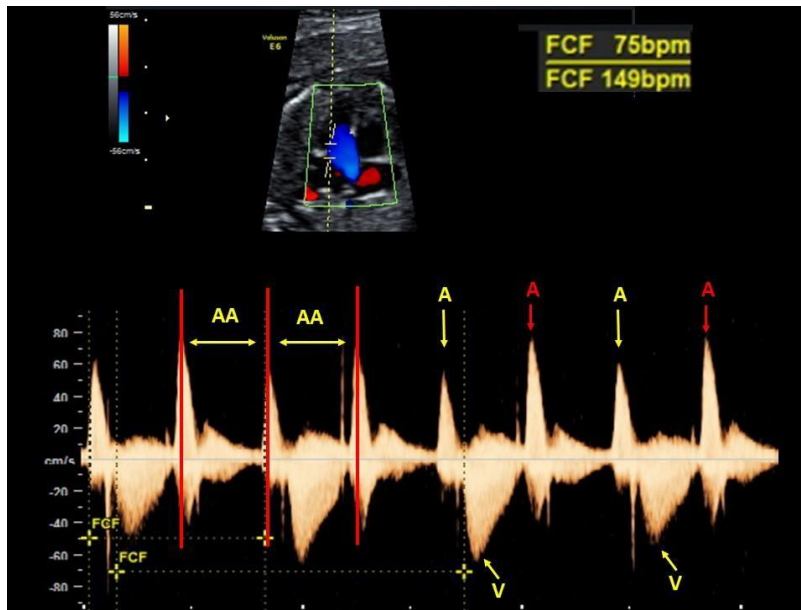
Grade II AVB. Mitral and aortic pulsed Doppler showing a regular atrial rhythm (constant AA interval) with conduction of one out of every two atrial beats (A) to the ventricle (V), causing a 2:1 AV ratio with a low ventricular rate (half the atrial rate).
